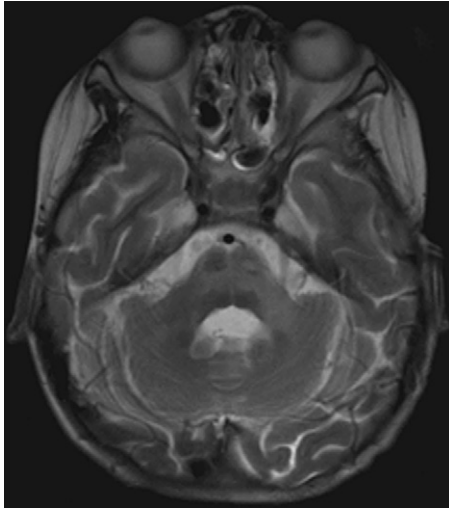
Radiologic manifestations in patient 4. Brain magnetic resonance imaging revealed demyelination in the left hemisphere (more than the right), as well as in the pons and the left pedunculus cerebellaris and dentate nucleus.
